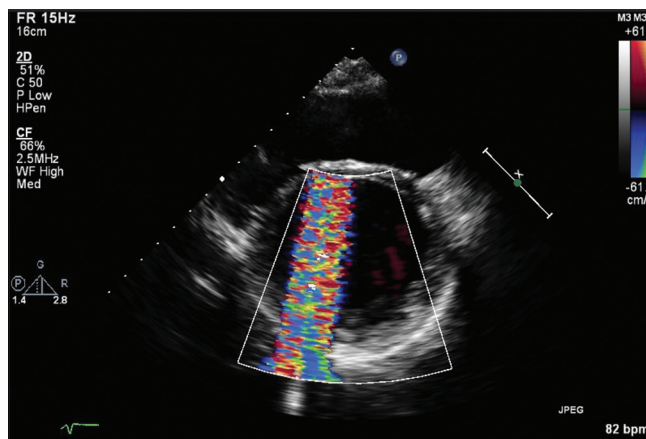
Transthoracic echocardiography on initial presentation. No definite flow seen across the inflow cannula. However, there remains minimal aortic valve opening with no significant changes in LV dimensions
